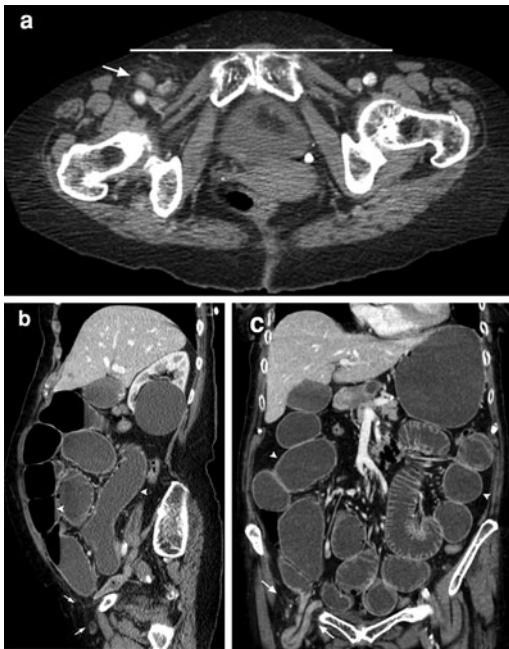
Strangulated femoral hernia in a 75-year-old woman. a The axial contrast-enhanced reformatted CT image of the abdomen shows a strangulated right hernia entirely located posterior to the orthogonal lines drawn at the pubic tubercle. Mural enhancement of herniated bowel is normal (similar to that of intra-abdominal bowel loops). b, c Sagittal and coronal contrast-enhanced reformatted CT images of the abdomen more clearly show the amplitude of the wall defect (*arrows*), air–fluid levels, and dilatation of intra-abdominal bowel loops secondary to small bowel obstruction (*arrowhead*)
